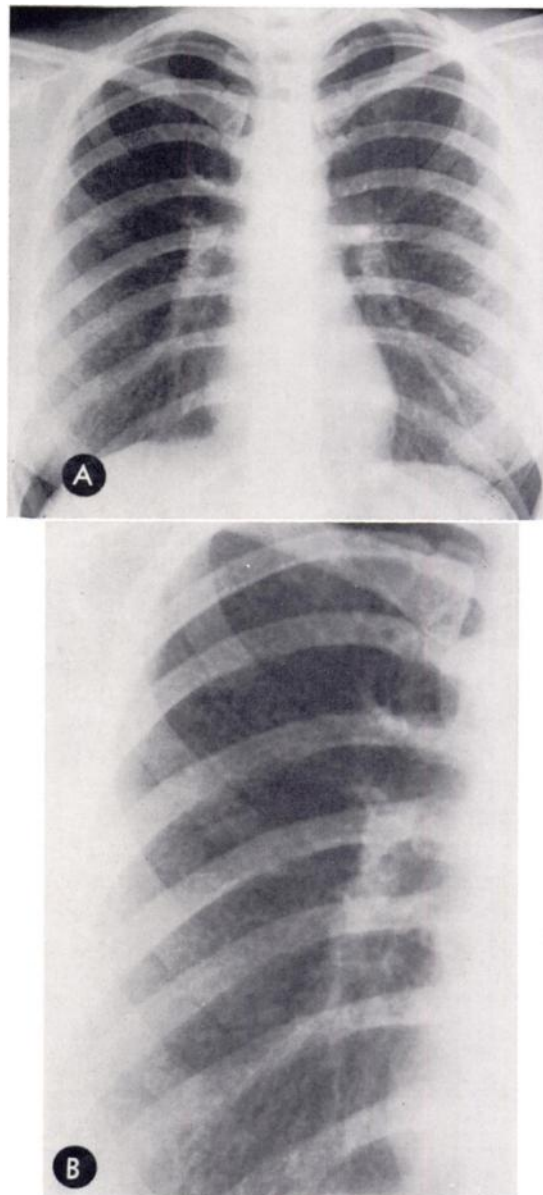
(A) Posteroanterior (PA) roentgenogram of the chest. Micronodular pattern; 18 year old female. Dyspnea for 1 month. (B) Detail, same patient.
